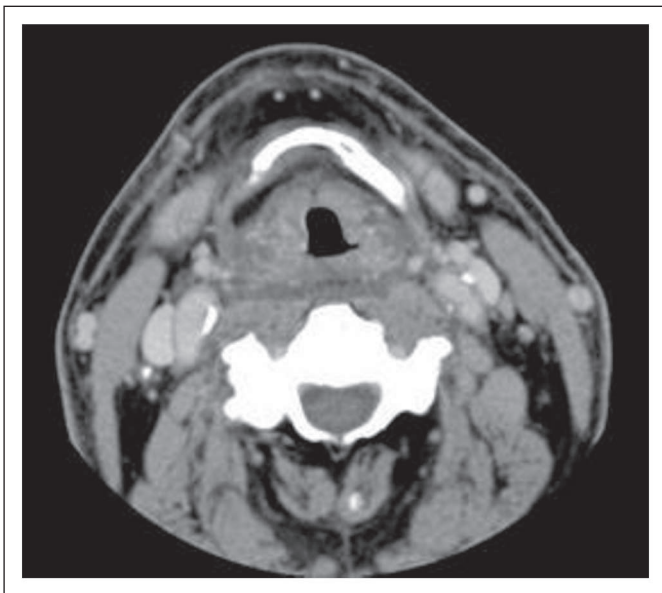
This 53-year-old patient received chemoradiotherapy (70 Gy at 2 Gy/fraction every day with fluorouracil/cisplatin) for T3N2b false vocal cord cancer. Postradiotherapy computed tomography demonstrated a residual 0.5-cm lymph node with definite calcification in the right neck and incidental calcifications in the carotid vessels. Neck dissection was positive. The patient was controlled with 4.5 years of follow-up.
